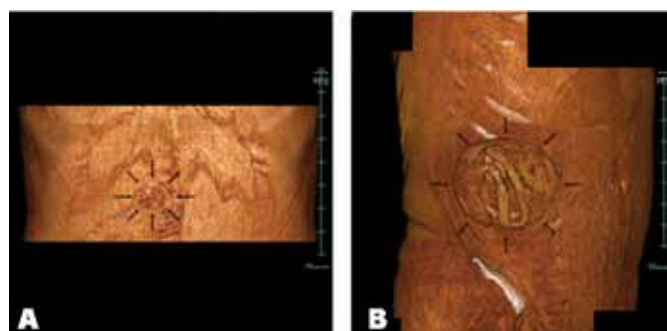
The three-dimensional computed tomography reconstruction images of the incisional hernias. (A) The image showing the midline incisional hernia of Patient 1 (Black arrows). (B) The image showing the right subcostal incisional hernia of Patient 2 (Black arrows). The content was almost intestines.
